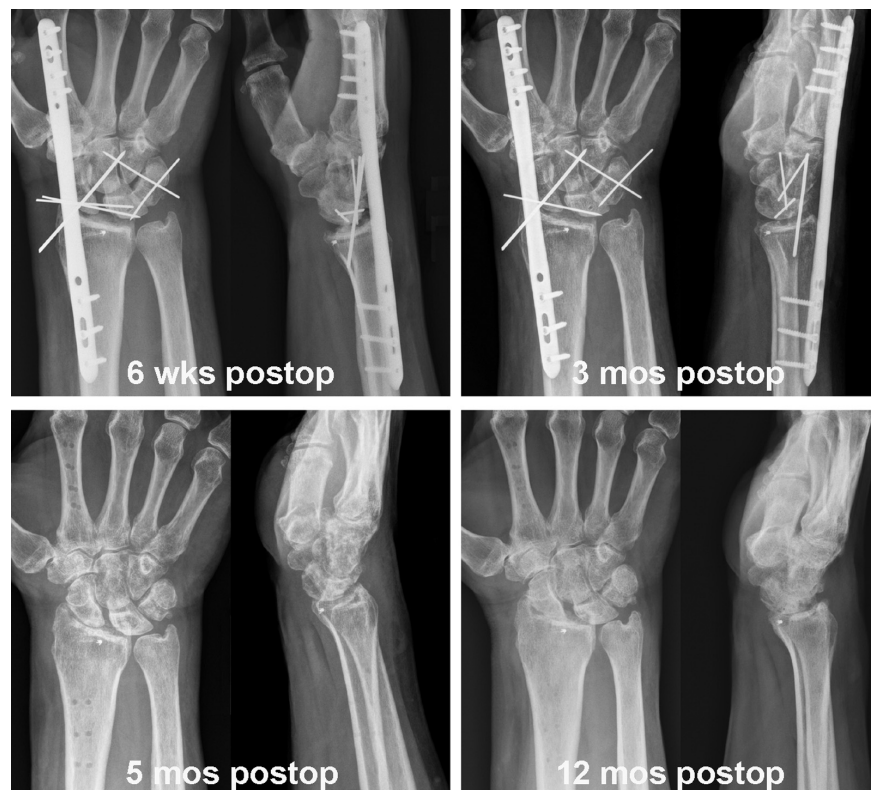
Postoperative radiographs (PA and lateral views) with associated time frame labels. One of the SL pins migrated and was removed between 6 weeks and 3 months. At 12 months, there was evidence of posttraumatic arthritis, mild ulnocarpal translation, and SL widening with DISI deformity. The DRUJ remained stable. Despite radiographic findings, functional outcome was satisfactory. DISI, dorsal intercalated segment instability; DRUJ, distal radioulnar joint; PA, posteroanterior; SL, scapholunate.
